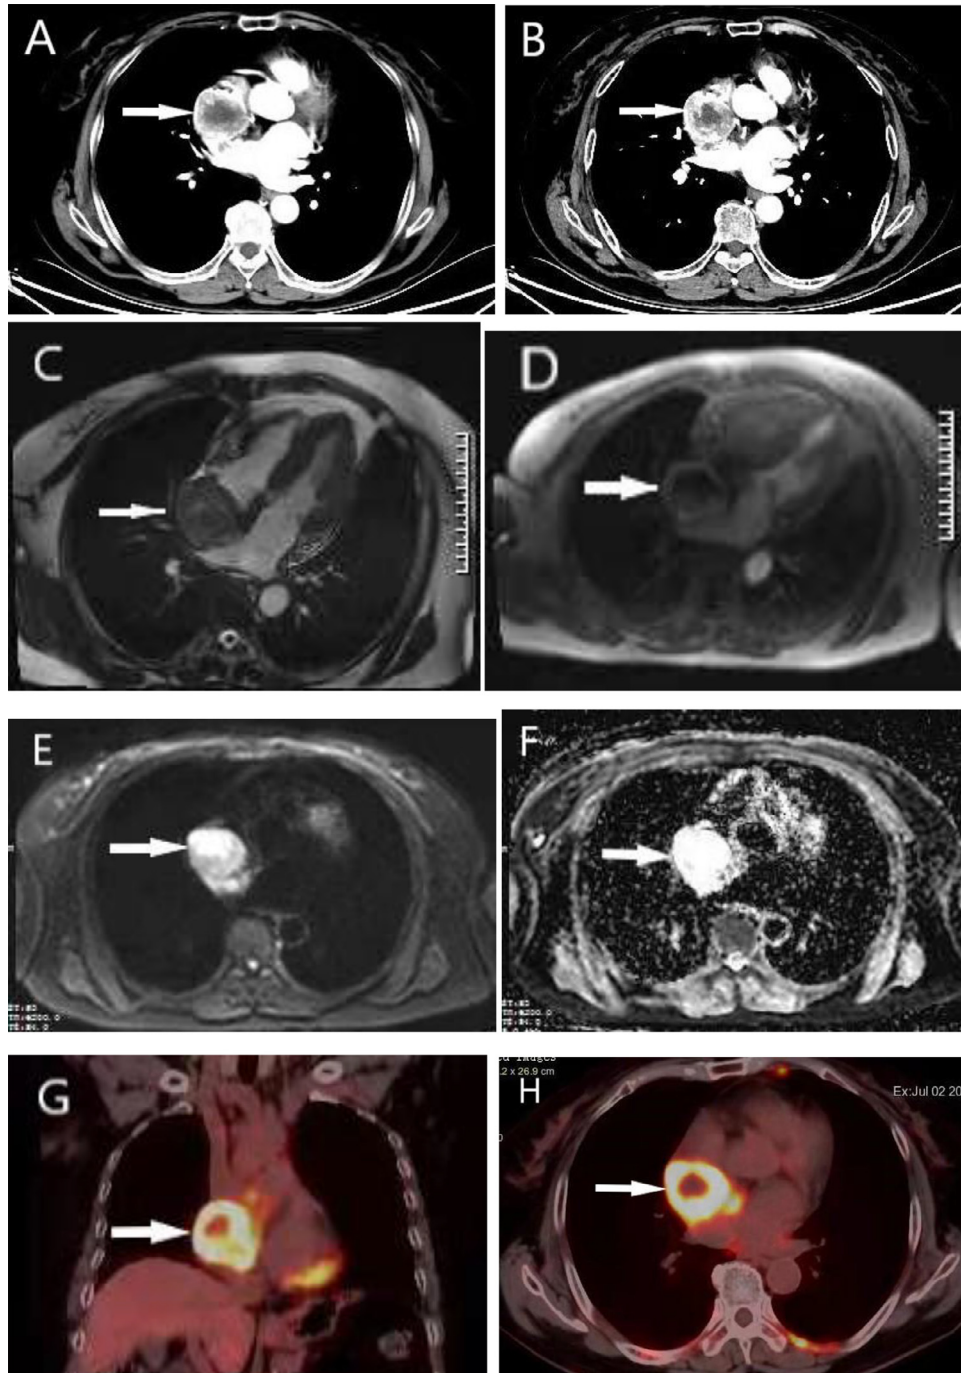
(A-B) Contrast-enhanced CT imaging. (C-F) CMR images. (G-I) PET-CT images. (J) Echocardiographic image. (K-L) Pathologic images. The arrows indicate lesions.
